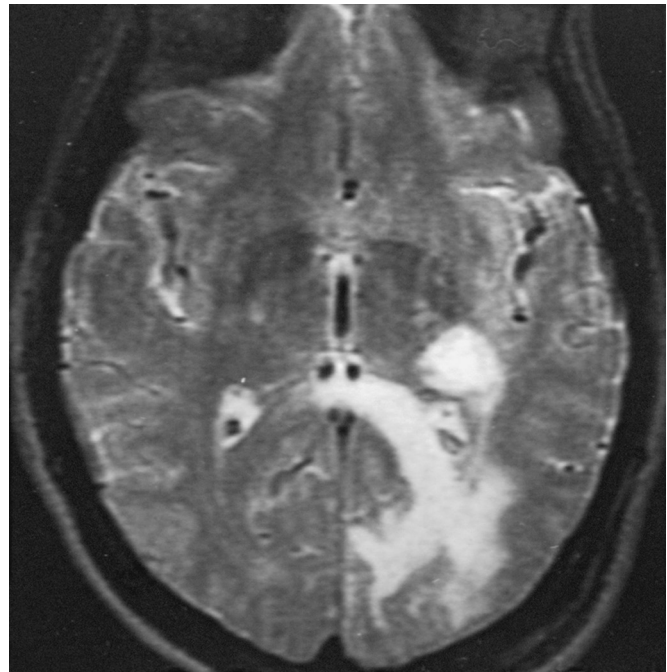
■ Progressive multifocal leukoencephalopathy (PML): axial T2-weighted MRI showing multifocal involvement of cerebral white matter.
